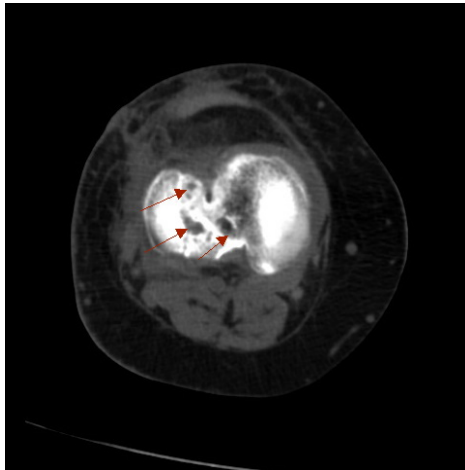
Recovery of cancellous bone structure after the repair with non-demineralized cancellous bone graft (spiral computed tomography). Large cysts (*arrows*) are visualized
